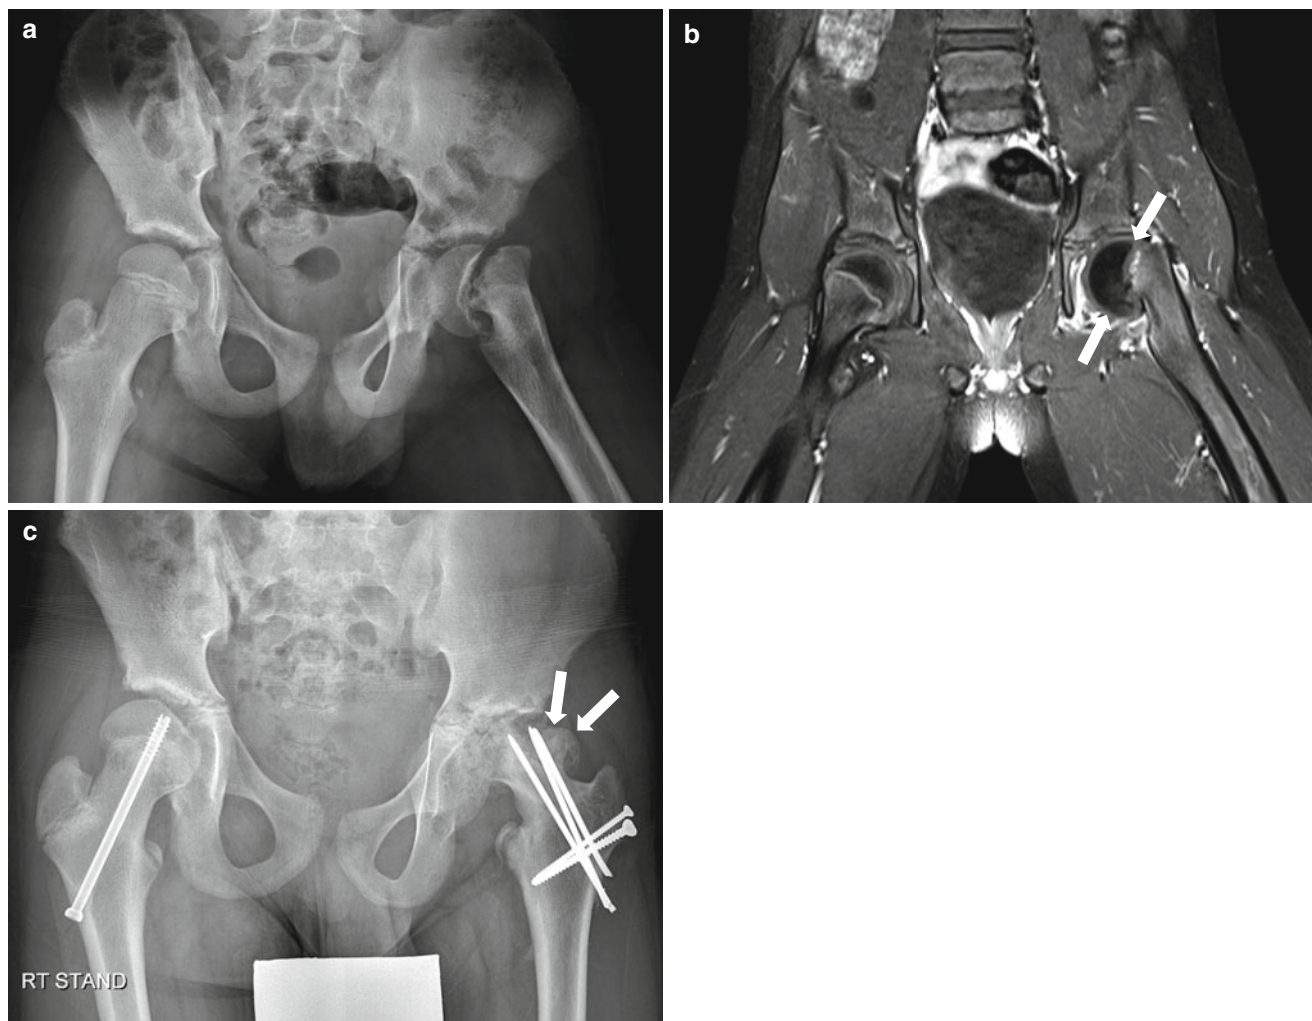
Avascular necrosis of the femoral head in a 13-year-old boy with severe slipped capital femoral epiphysis. (a) Anteroposterior radiograph shows severe displacement of the femoral capital epiphysis and widening of the proximal femoral growth plate. (b) Contrast-enhanced T1-weighted image demonstrates slipped femoral epiphysis
